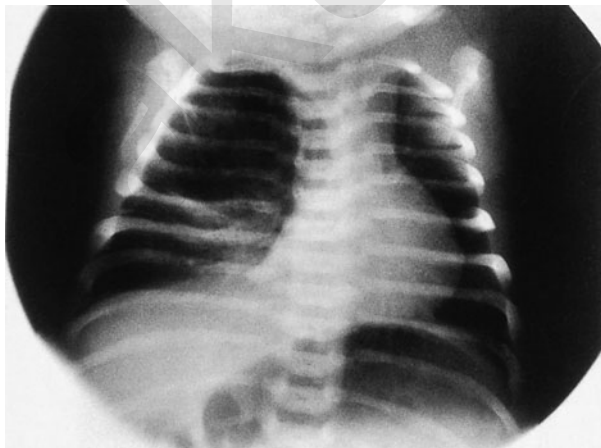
Congenital lobar emphysema. Chest x-ray in a 3-day-old infant who presented with respiratory distress, showing marked hyperinflation of right upper lobe.
